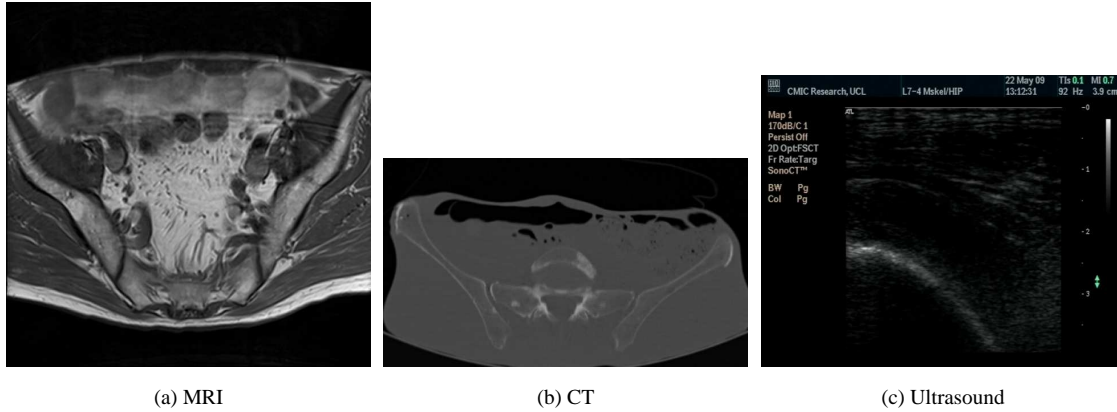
Ultrasound (c) and CT (b) images of bone have broadly similar appearance, the bone edge appears as a bright line on the image. On a T2 weighted MRI (a) image of the same anatomy the bone edge does not appear as a bright line. The thick cortical bone appears as a dark line around the perimeter of the trabecular bone in the centre of the pelvic bone. Registering ultrasound to CT is a proven process. Registering MRI to ultrasound for the pelvic bone is untried.
